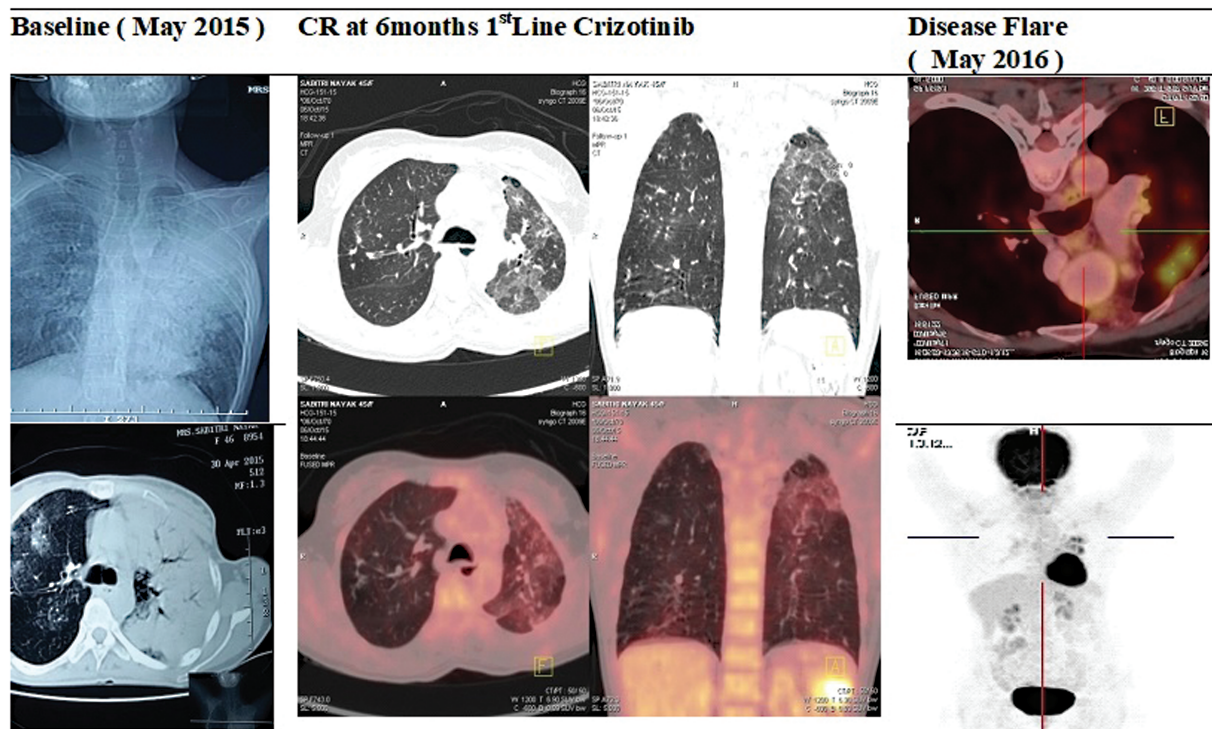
Positron emission tomography-computed tomography (PET-CT) findings reflecting a complete metabolic response after 6 months of therapy.
